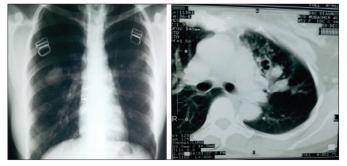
Radiological appearance of high attenuation mucous on CXR and HRCT chest.
